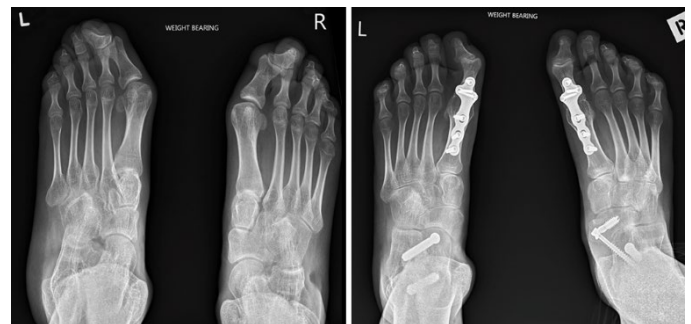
AP weight-bearing radiographs before and after bilateral arthrodesis of the 1st MTPJ for hallux valgus combined with extra-articular subtalar fusion for severe pes valgus. The patient was an adolescent with severe foot deformities and crouch gait. The hallux valgus angle is fully corrected, the intermetatarsal angle has reduced but the interphalangeal angle has increased.
